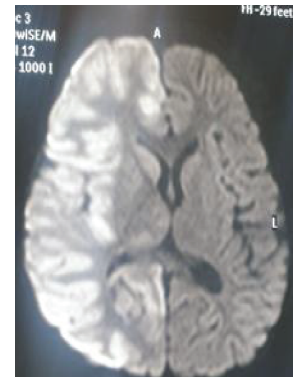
Hyperintensity in DWI involving right hemisphere at 25 month of age
